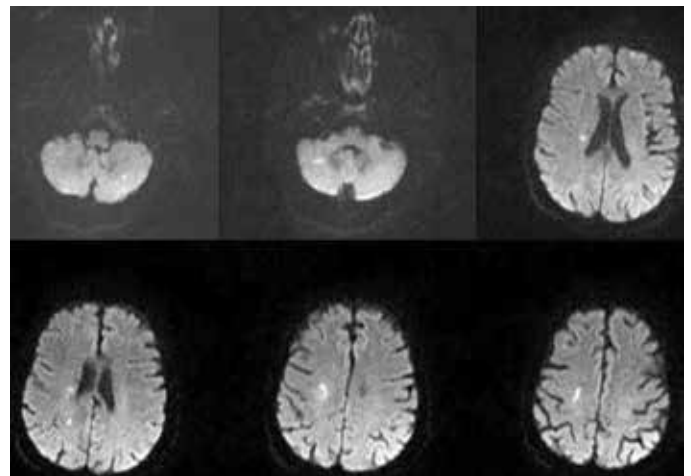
Diffusion obstruction in the bilateral cerebella hemisphere and right centrum semiovale that is compatible with multiple acute infarction areas seen in the diffusion-weighted MRI of the second patient
